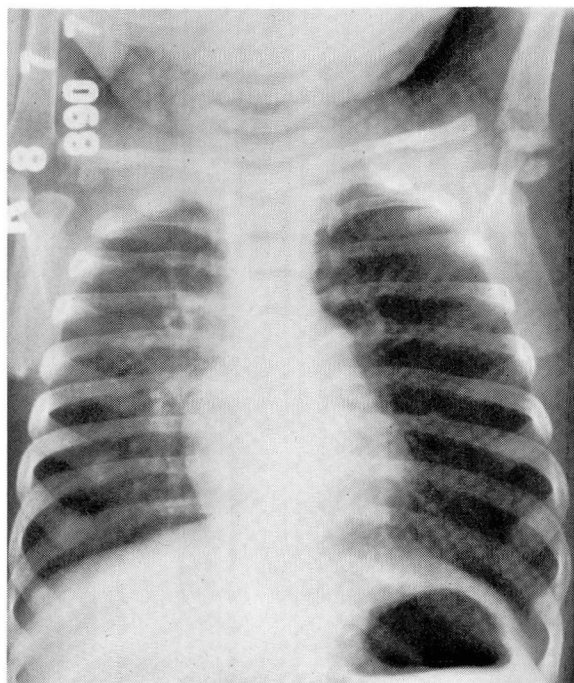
Case 3. Roentgenogram of the chest, demonstrating massive emphysema of the left lung.
